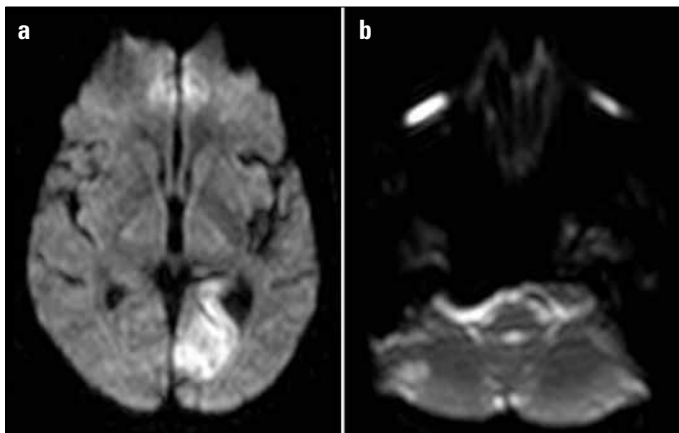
a, b. Brain diffusion MRI (b1000): demonstrated acute infarct areas in the left occipital (a) and bilateral cerebellar lobes (b)
